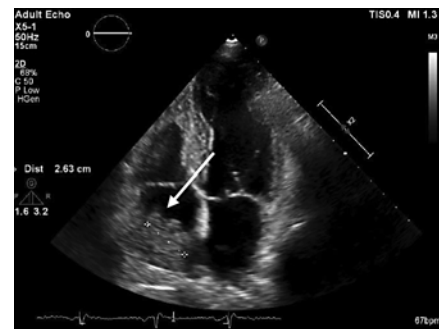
Preoperative echocardiogram revealed the 2.63 cm mass or thrombus occupying the RA without tricuspid involvement nor being of the pedunculated type (white arrow).
